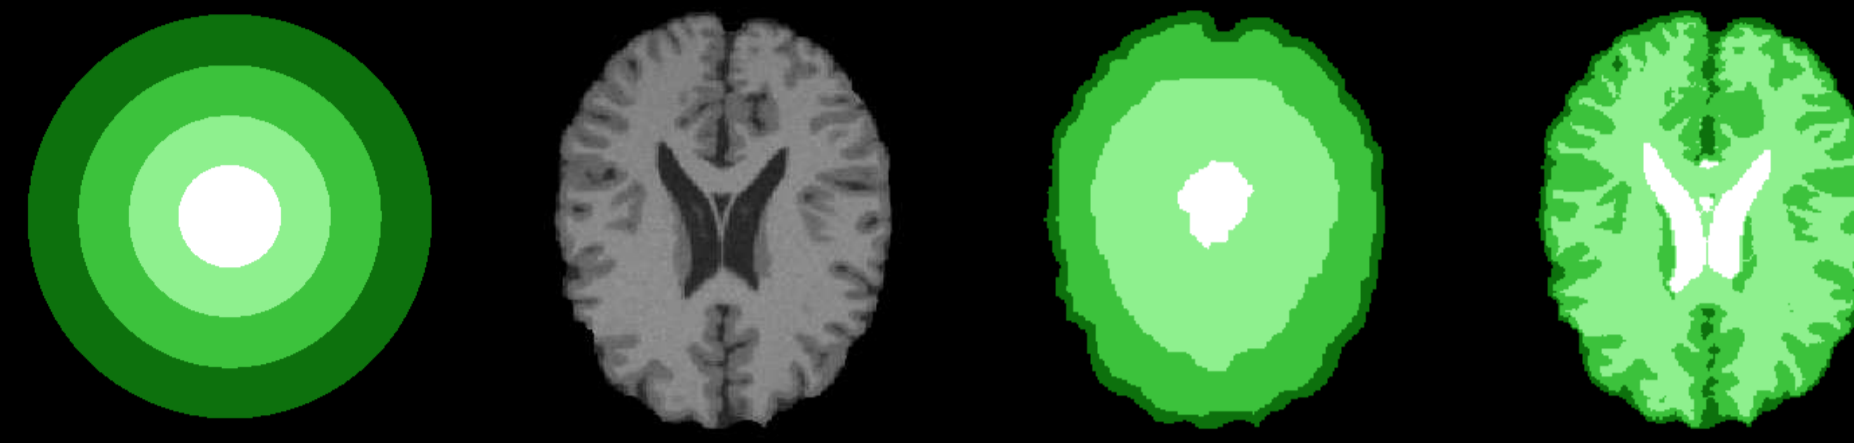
From left to right: topological model (from white to dark green: C_v^i , C_w^i , C_g^i , and C_s^i); T1 MRI ($I|_{E'}$: axial slice); initialisation of the segmentation process of the MRI (C^i); result of the segmentation (C).
